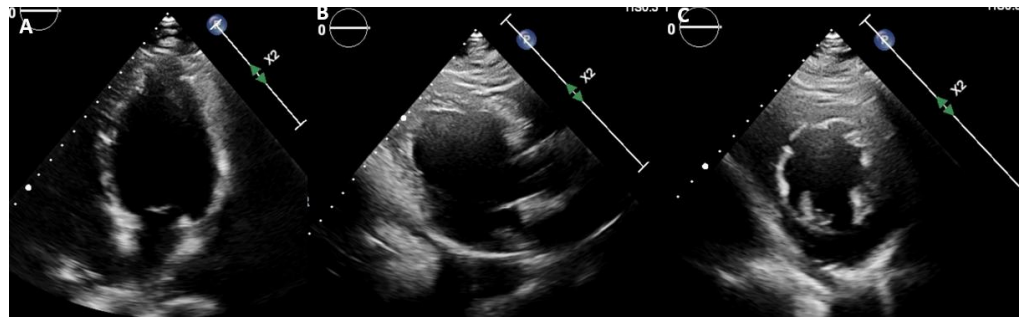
(A): Apical four chamber view
